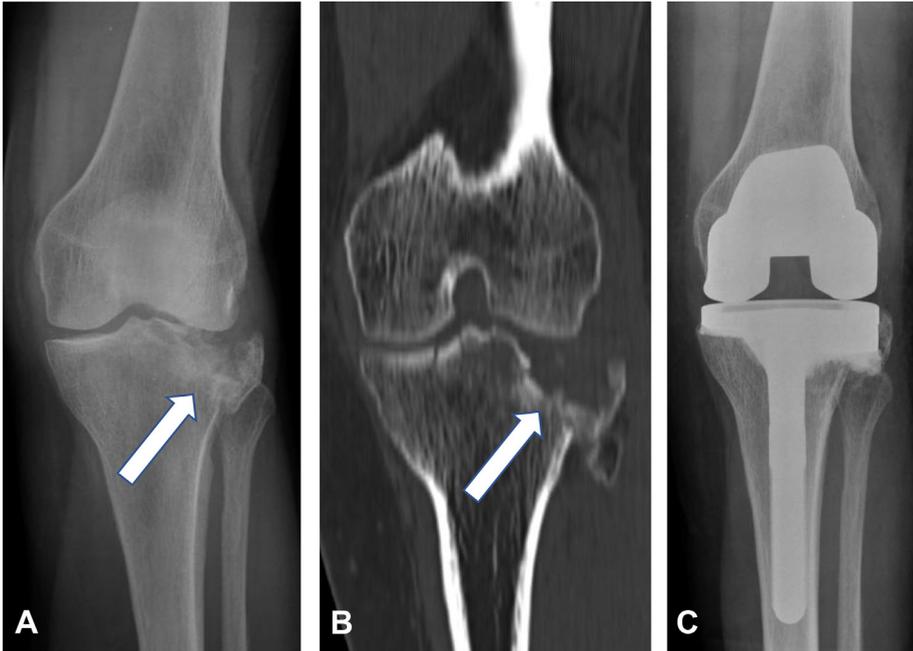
Fracture of the lateral plateau of the proximal tibia (A). Computed tomography shows destruction of lateral plateau in an osteopenic patient (B). Treatment consisted of inserting a total knee prosthesis with a lateral wedge to fill the defect (C).
